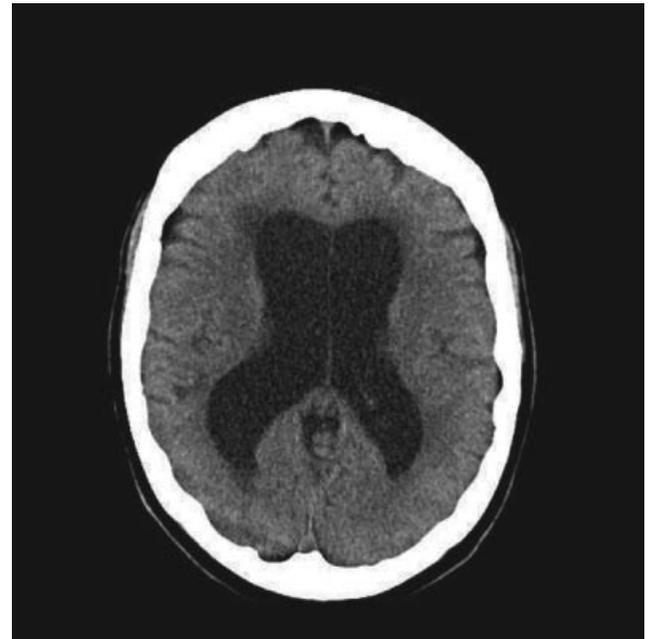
CT scan showing typical features of NPH, with ventricular enlargement out of proportion to cerebral atrophy.
